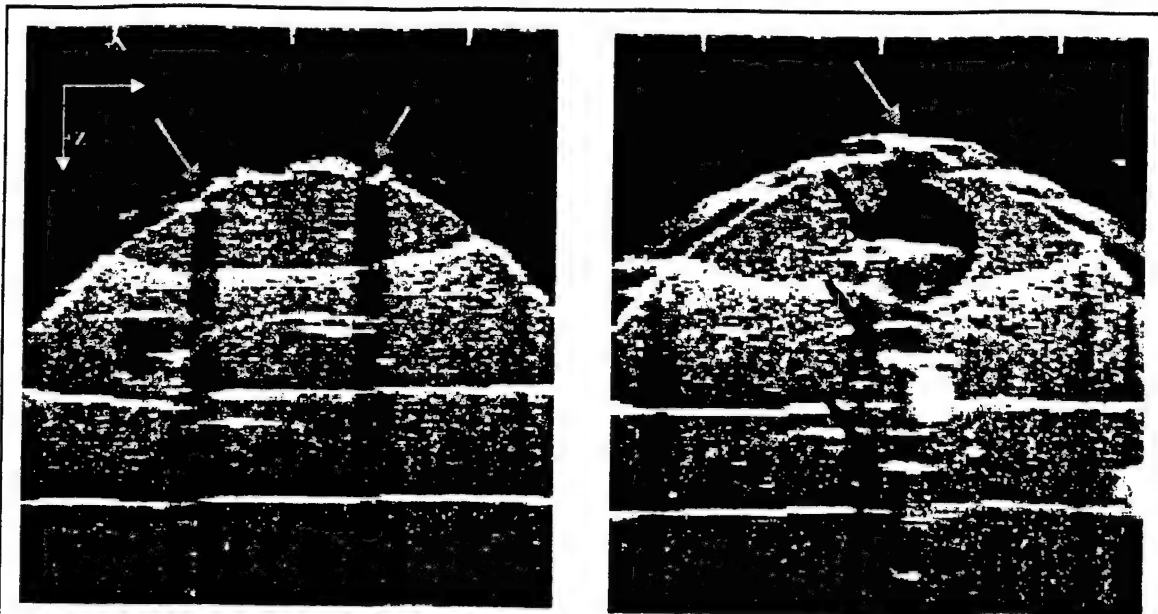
This shows the appearance of the ultrasound markers in a B-scan image. There are two possible artifacts associated with these markers. On the left, the markers create shadows where little ultrasound energy passes through the marker to tissue below. On the right, the marker happens to be normal to the transducer face and multiple reflections from the marker are seen.
